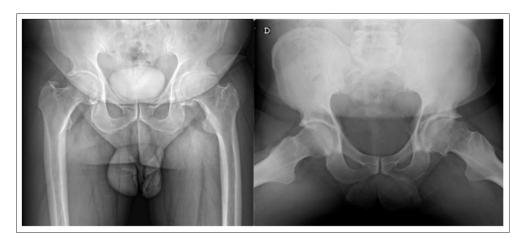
Hip x-ray Demonstrating Bilateral Hip Arthrosis (Tönnis grade 3).
